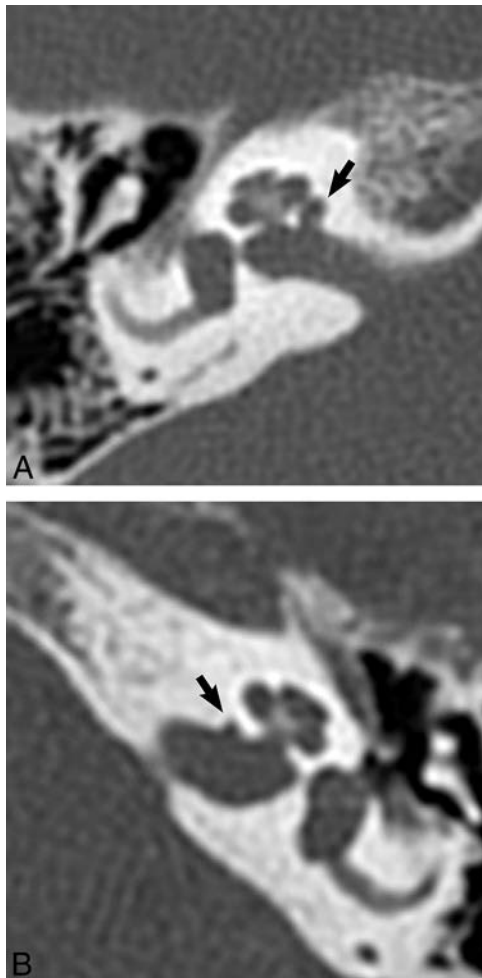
IAC diverticula on temporal bone CT. A, CT of the right temporal bone in a 41-year-old woman with vertigo. A CSF-density saccular outpouching of the anterior IAC medial to the cochlea is compatible with an IAC diverticulum (black arrow). B, CT of the left temporal bone in a 67-year-old woman undergoing evaluation of SNHL. A smaller diverticulum or notch is present along the anterior IAC in a location similar to that of the larger diverticula in A (black arrow).
